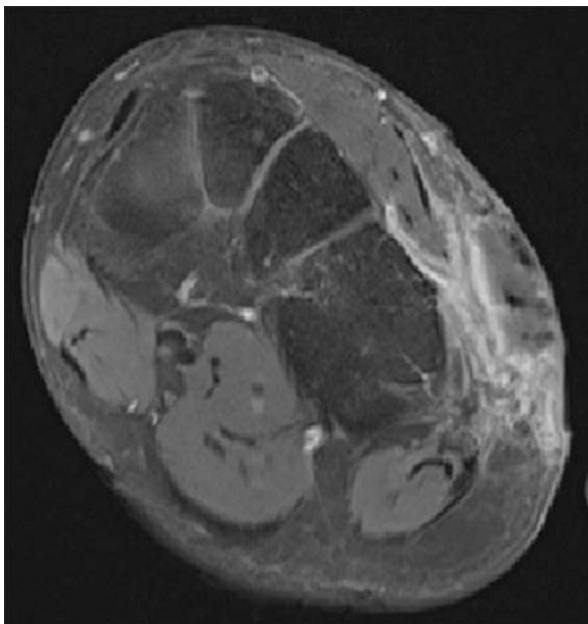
Pre-biopsy MRI of the left foot in a 34-year-old male with inadequate excision (positive margins) of dermatofibrosarcoma protuberans (DFSP) at the lateral aspect. Coronal fat-saturated T1 post-contrast-enhanced images demonstrate haematoma overlying the lateral cuboid within the subcutaneous tissues, and there is an extensive contrast enhancement adjacent extending deep into the extensor musculature and along the superficial surface of the cuboid bone. It is unknown whether the original tumour was confined to the subcutaneous tissues and/or if the deep enhancement within muscle and on the bone is a result of inadvertent surgical exploration. This makes biopsy of a target lesion very difficult, and the subsequent management even more so
